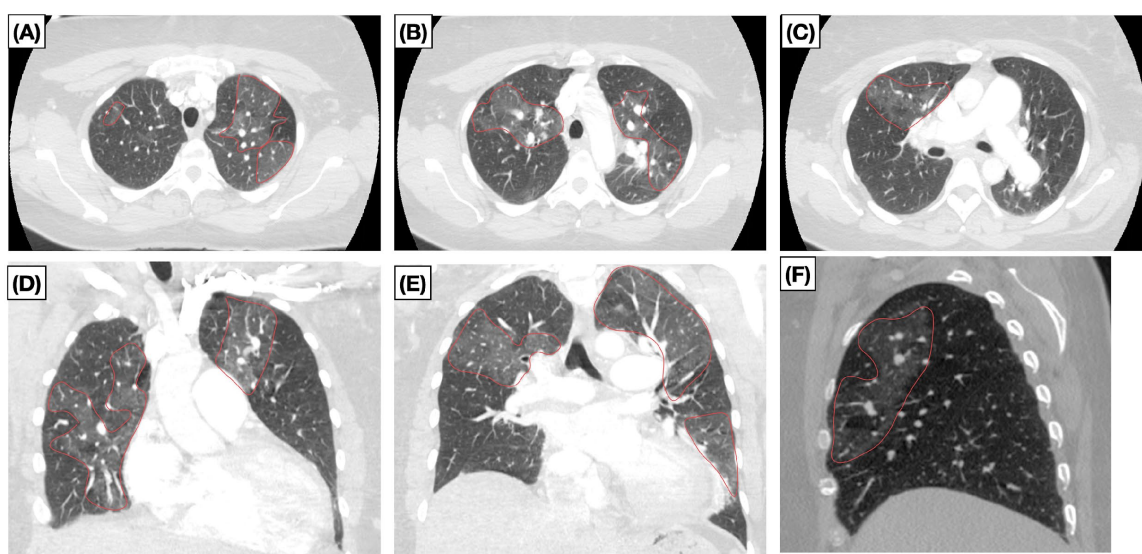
Patterns of mosaic perfusion on CT. Patterns of mosaic perfusion (red outline) as suggested by a mix of hypo-attenuation and hyper-attenuation segments of lung with sharply demarcated borders is highly suggestive of perfusion defects seen in chronic PE.
